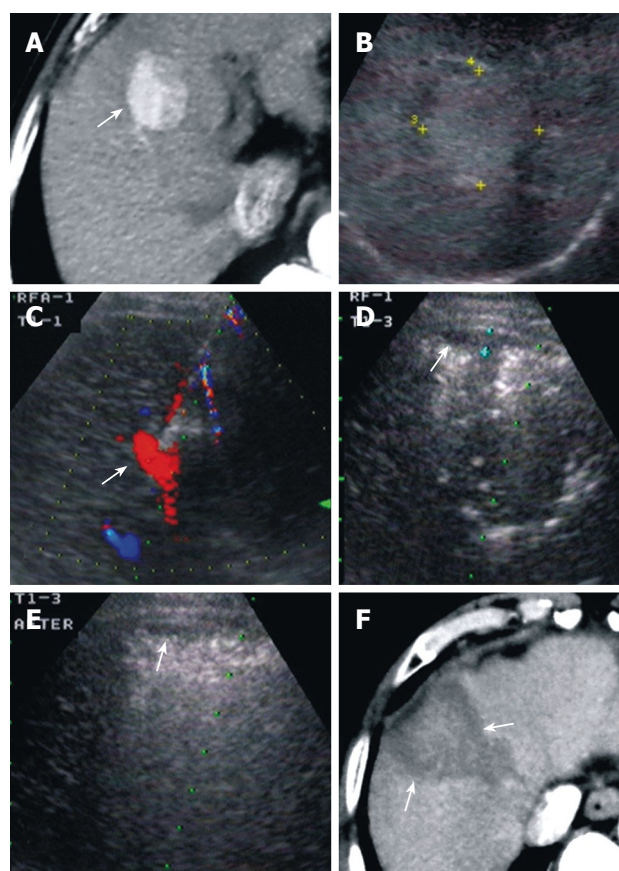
A 72-year-old man with 10 years of hepatitis B was detected with HCC during routine examination. This patient could not tolerate most of the therapies because of old age and poor general condition. A: Contrast-enhanced CT showed a 3.7 cm × 3.5 cm mass and the feeding vessel (arrow); B: Contrast-enhanced US 2 mo later showed the tumor enlarged to a size of 5.2 cm × 4.2 cm; C: CDFI showed feeding vessels in and around the tumor with a flow velocity of 34.5 cm/s. PAA was performed under CDFI guidance; D: During PAA, a small amount of subcapsular hemorrhage (0.5 cm in depth) was noted; E: The amount of hemorrhage gradually reduced (arrow) after PAA finished; F: Contrast-enhanced CT (24 h after treatment) showed a necrotic area covering the tumor. A small amount of subcapsular hemorrhage was still be noted.
